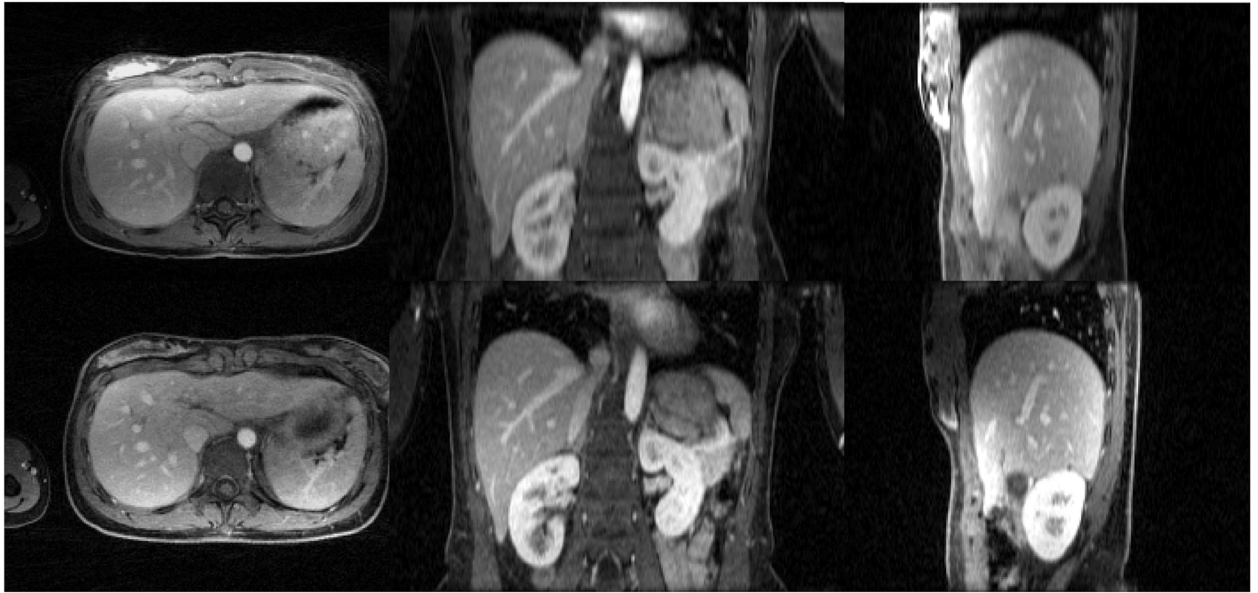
Comparison of liver DCE-MR images with stack-of-stars sampling and VD-stack-of-stars sampling in a venous phase in the third subject. Similar improvement of image quality, sharpness and conspicuity can be observed in the VD-stack-of-stars results.
